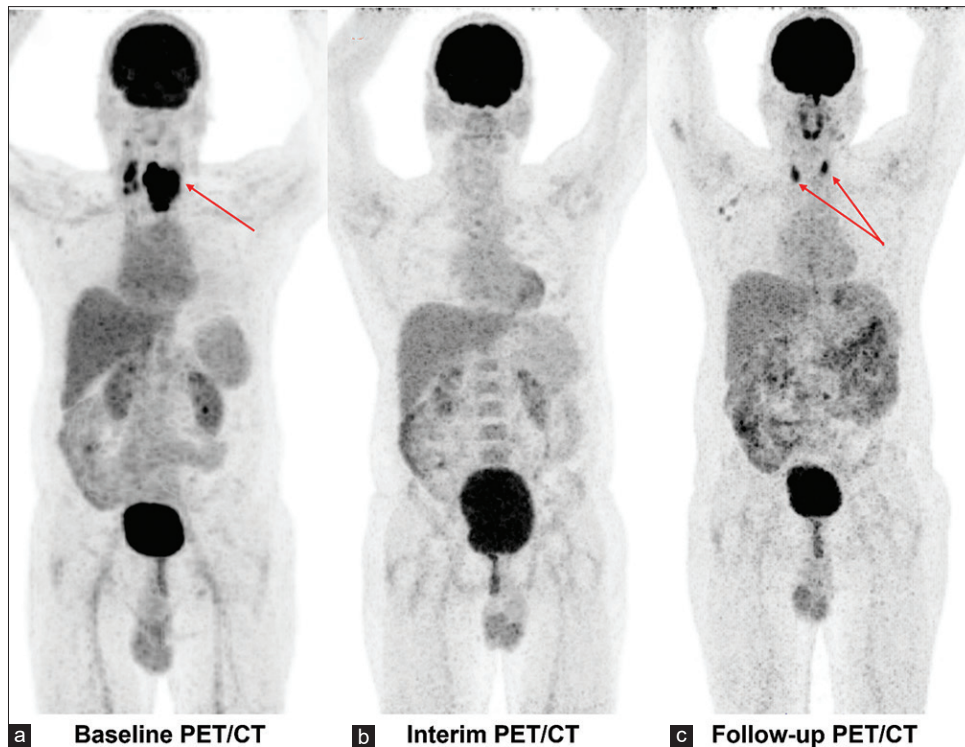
Baseline image (a) revealed increased tracer uptake in a large mass in the thyroid region (red arrow), interim image (b) revealed no significant uptake suggestive of excellent response to chemotherapy. End cycle PET/CT suggestive of excellent response (not shown). The patient developed recurrent thyroid swelling after one year. Follow-up image (c) revealed increased uptake in the bilateral thyroid lobe suggestive of recurrence (red arrow) which turned out to be a false positive on Biopsy
